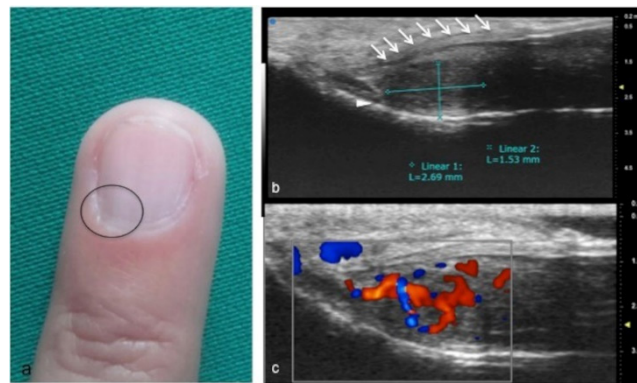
Glomus tumor in the subungual space. No clear alterations were visible during clinical examination at the site of pain (circle in (a)). In (b), UHFUS effectively demonstrates the presence of a hypo-isoechoic nodule (calipers) in contact with the adjacent phalangeal bone (arrowhead) under the nail plate (arrows). Note the small deformation of the nail plate. Mild vascularization on color Doppler was present (c).
